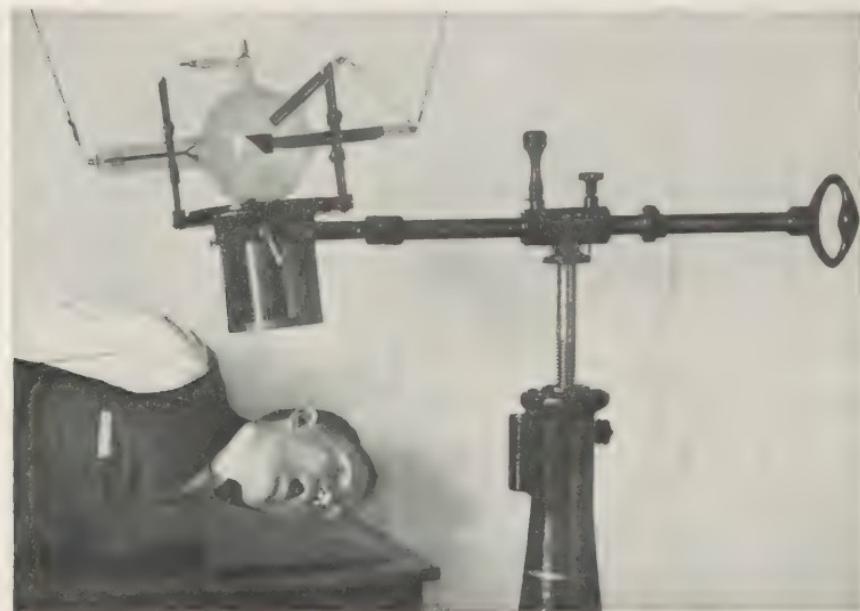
Position for lateral roentgenography of head.
